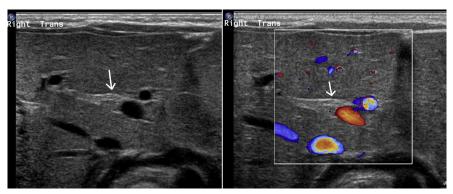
Abdominal US in BA. Triangular-shaped homogenous echogenicity near the bifurcation of the portal vein consistent with triangular cord sign. *White arrows* indicate triangular cord of hyperechoic fibrous tissue seen at the porta hepatis. *Square* on figure at right indicates application of Doppler, highlighting vascular structures.
